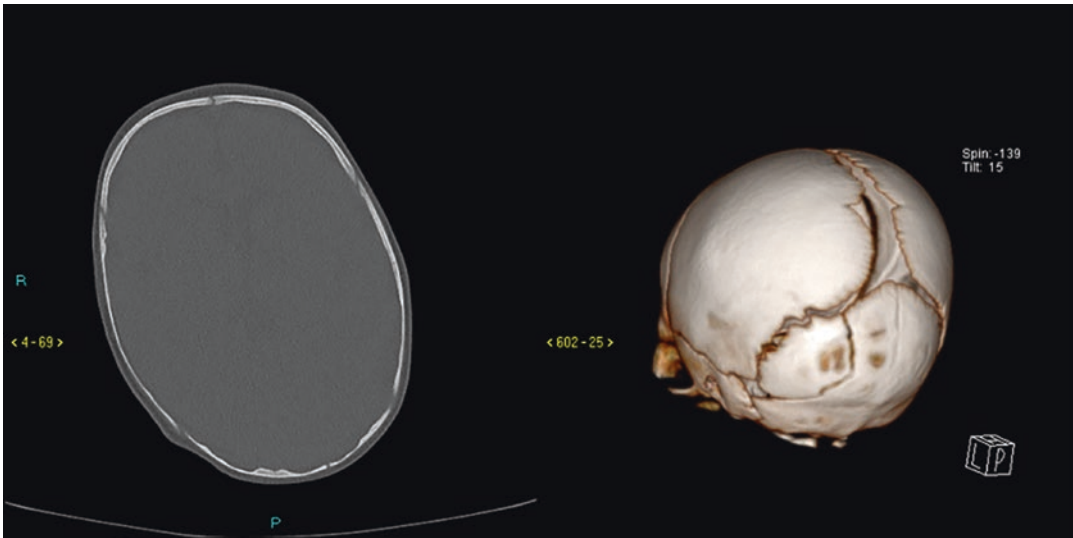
Left: Thin slice CT head (bone reformat) showing an asymmetrical defect in the left occipital bone. Right: 3D reconstruction demonstrates an accessory left occipital suture
